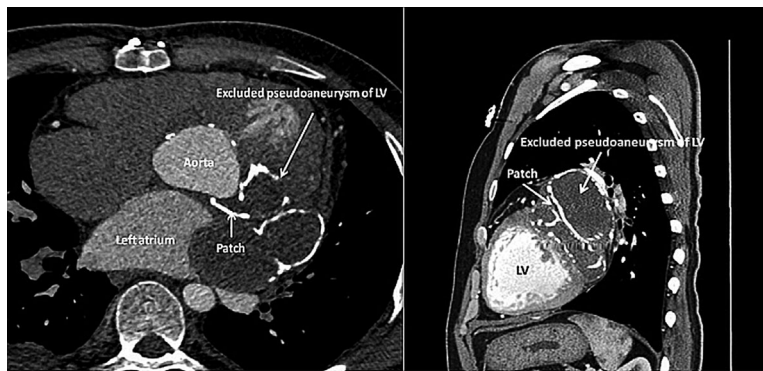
Postoperative computed tomography showing excluded pseudoaneurysm of LV and patch in transverse section (A) and in sagittal view (B) (arrows). LV, left ventricle.
